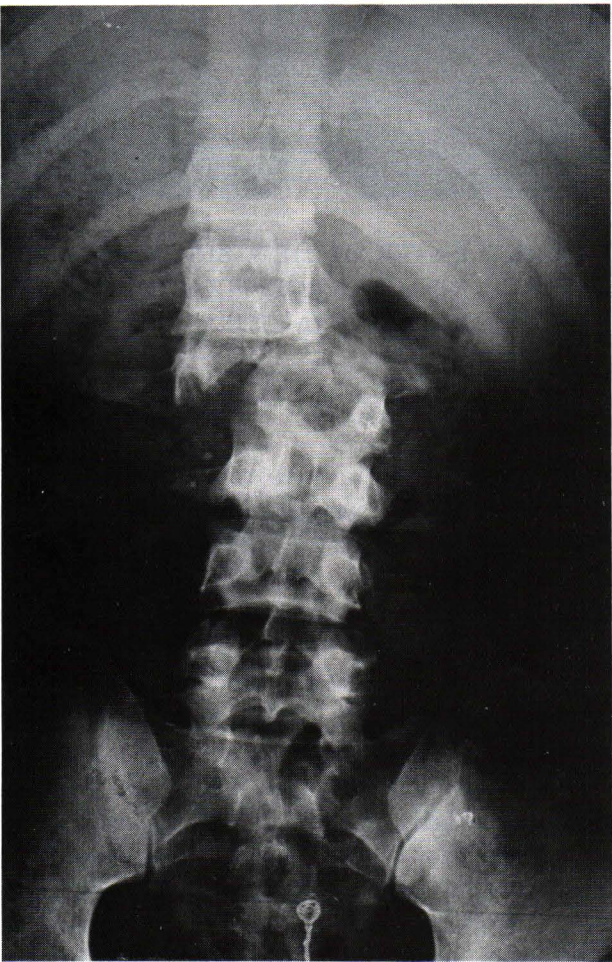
A-P X-RAYS SHOWING UNSTABLE FRACTURE AT T12-L1
